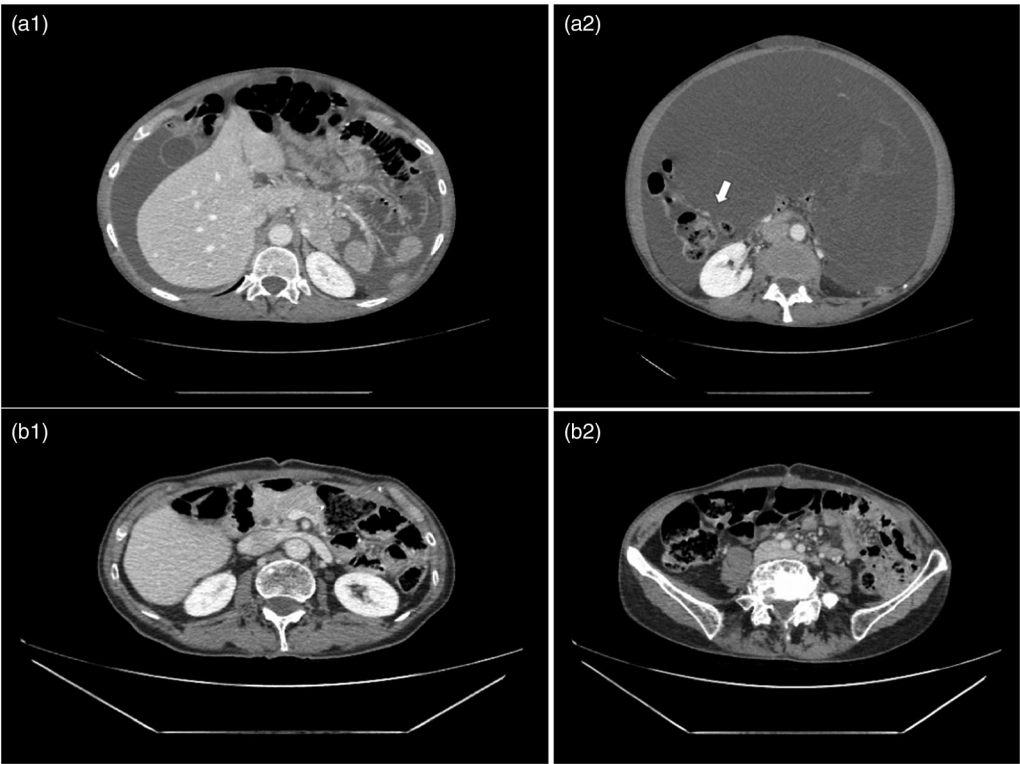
Radiological evaluation before surgery. (a) Axial contrast-enhanced CT images prior first stage surgery shows ascites (a1) and a large ill-defined multicystic mass within the abdominal cavity (a2). This complex cystic mass is seen repressing the intraperitoneal organ such as the right colon (a2 arrow). (b) Axial contrast-enhanced CT images performed just before the second time surgery show in comparison to images a1 and a2 the complete disappearance of ascites and of the complex cystic mass with the intraperitoneal organ back in their proper position in the abdominal cavity. Those results are in keeping with a complete radiological response of the first stage CRS/HIPEC oxaliplatin 250mg/m²
